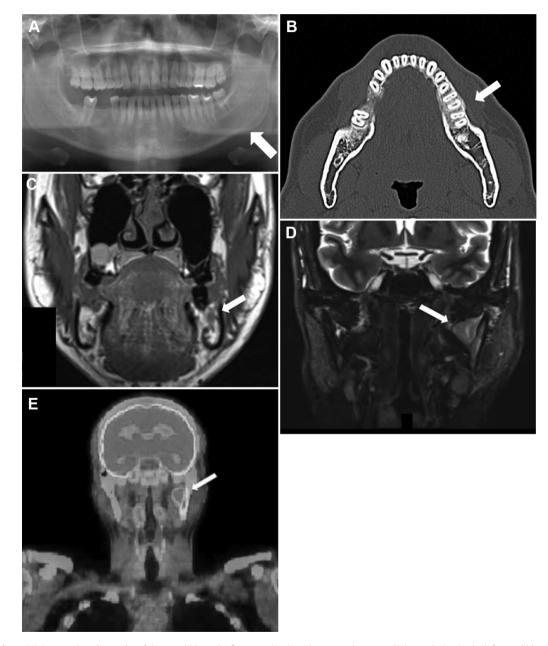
Image findings. (A) Panoramic radiography of the mandible at the first examination (the arrow shows a radiolucent lesion in the left mandible possibly indicative of osteonecrosis or osteomyelitis). (B) Computed tomography values in the mandibular first and second molar surrounding the bone were higher than another region. (C) Magnetic resonance image showing infection of left side mandible bone on T1-weighted coronal images. (D) Magnetic resonance image showing a soft tissue formation measuring 26 mm, continuous with the bone cortex in the left mandibular notch on T2-weighted coronal images. (E) Fludeoxyglucose (¹⁸F)-positron emission tomography–computed tomography (the arrow shows left mandibular notch image). Left side mandibular notch; SUVmax: 8.19.
